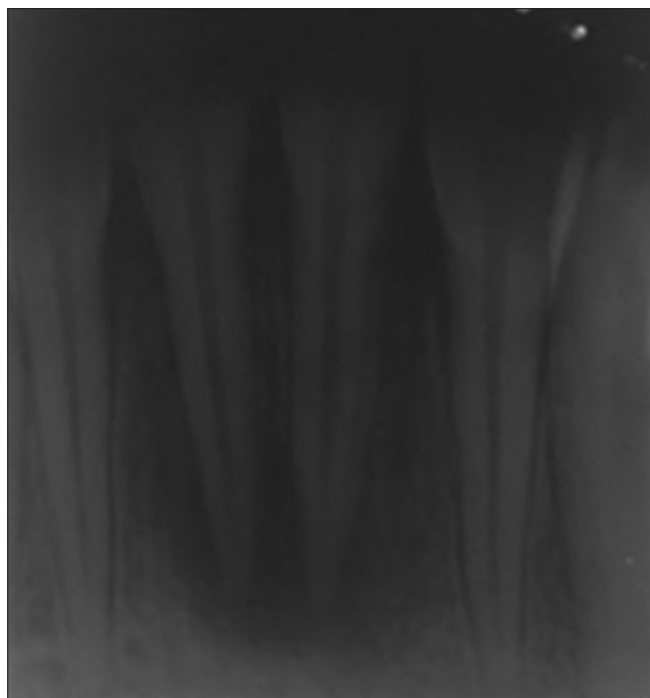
Intraoral periapical radiograph showing periapical lesions in relation with 31 and 41
